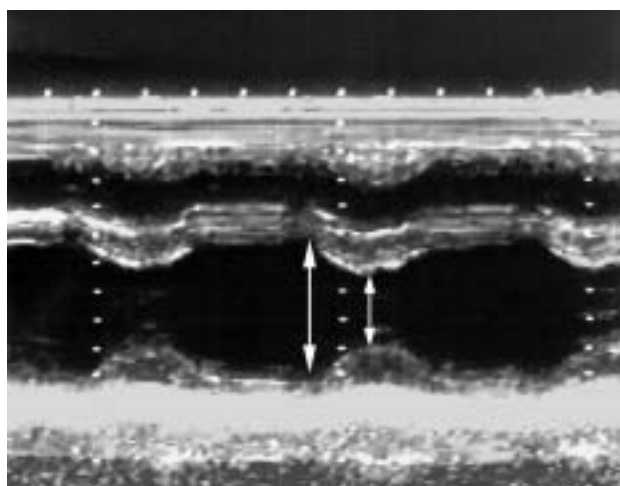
Before discharge, the echocardiogram revealed full recovery of myocardial contractility (ejection fraction 60%). The end-diastolic and end-systolic diameters (arrows) were 43 mm and 25 mm (shortening fraction 42%).
